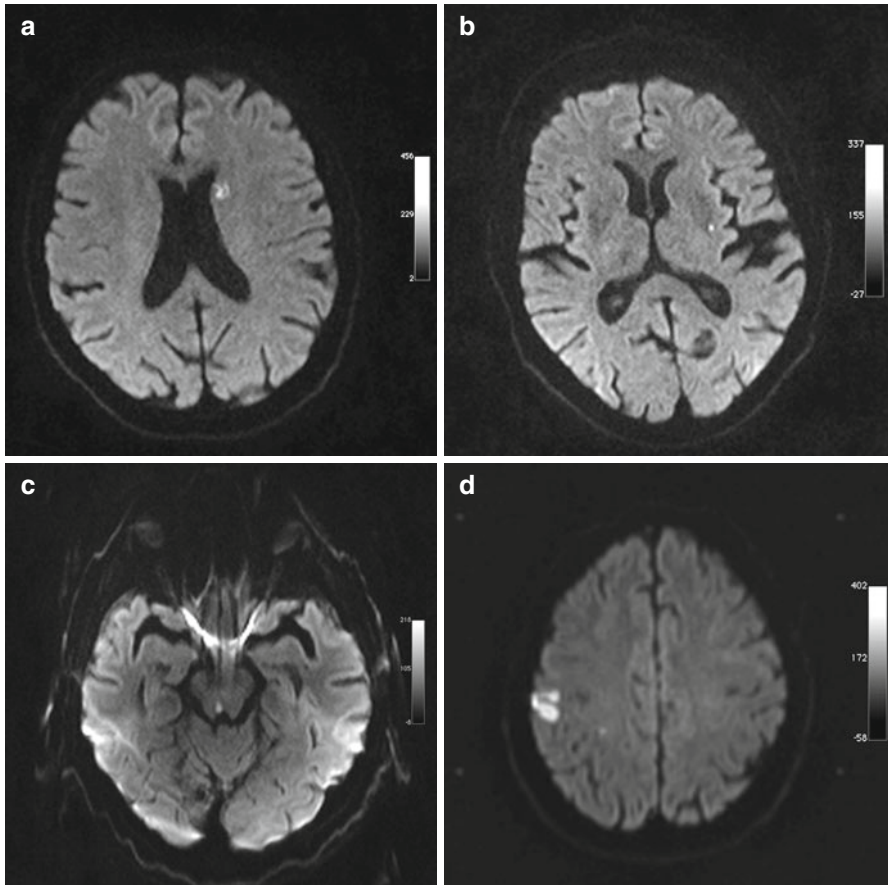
Incidental screening findings in several subjects (DWI at $b=1,000$ s/mm²). (a) A 72-year-old male subject with abnormal perfusion in the left frontal periventricular white matter. (b) 69-year-old male subject with punctiform lacunar ischemia of the left external capsule. (c) A 53-year-old female subject with fresh lacunar ischemia in the right periaqueductal region. (d) A 78-year-old male subject with small cortical middle cerebral artery infarction on the right and small subcortical lacunar lesion in the mid-portion of the middle cerebral artery territory
